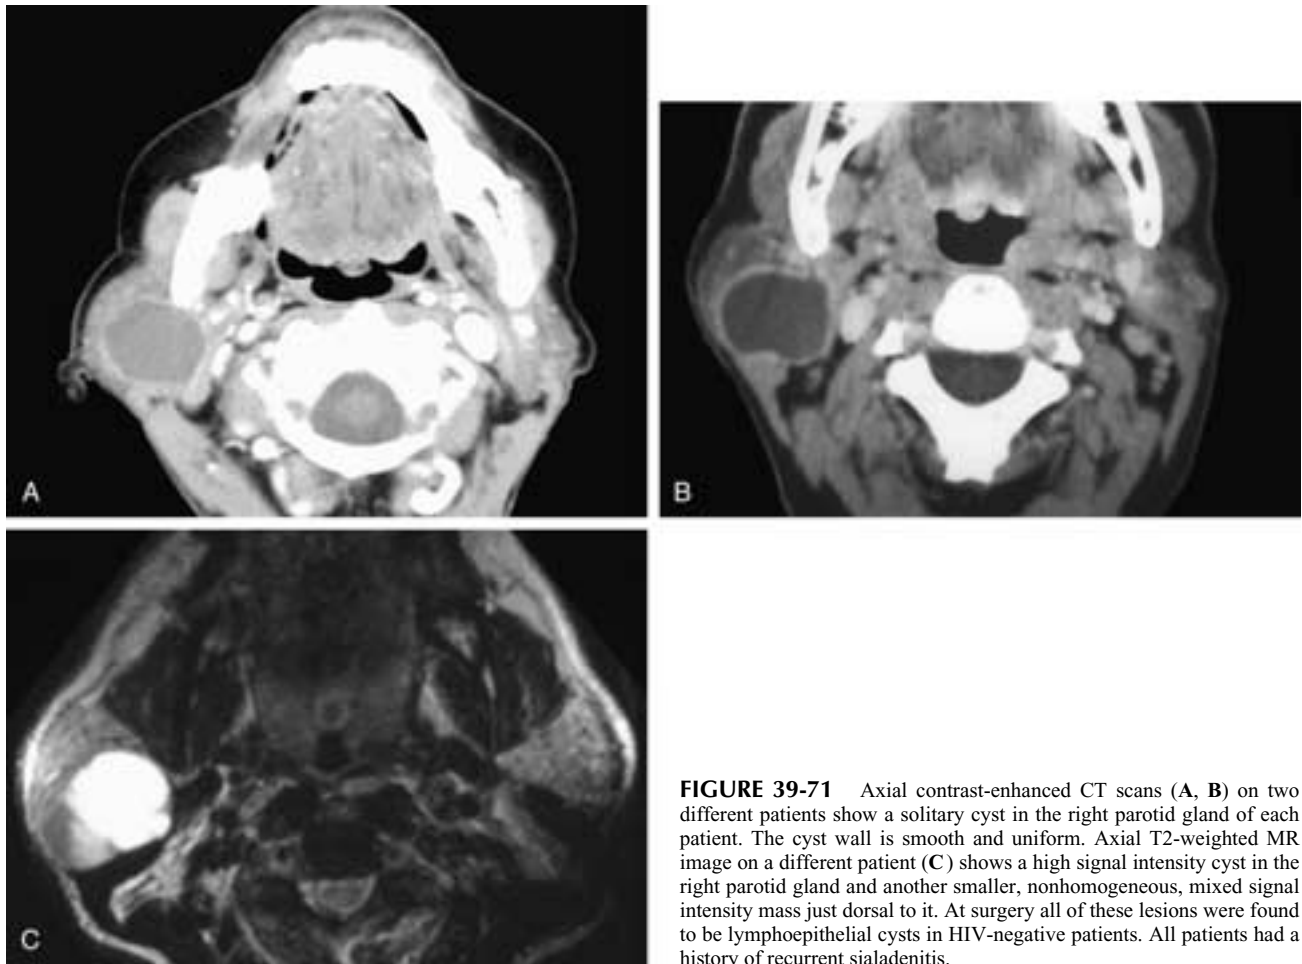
Axial contrast-enhanced CT scans (A, B) on two different patients show a solitary cyst in the right parotid gland of each patient. The cyst wall is smooth and uniform. Axial T2-weighted MR image on a different patient (C) shows a high signal intensity cyst in the right parotid gland and another smaller, nonhomogeneous, mixed signal intensity mass just dorsal to it. At surgery all of these lesions were found to be lymphoepithelial cysts in HIV-negative patients. All patients had a history of recurrent sialadenitis.
